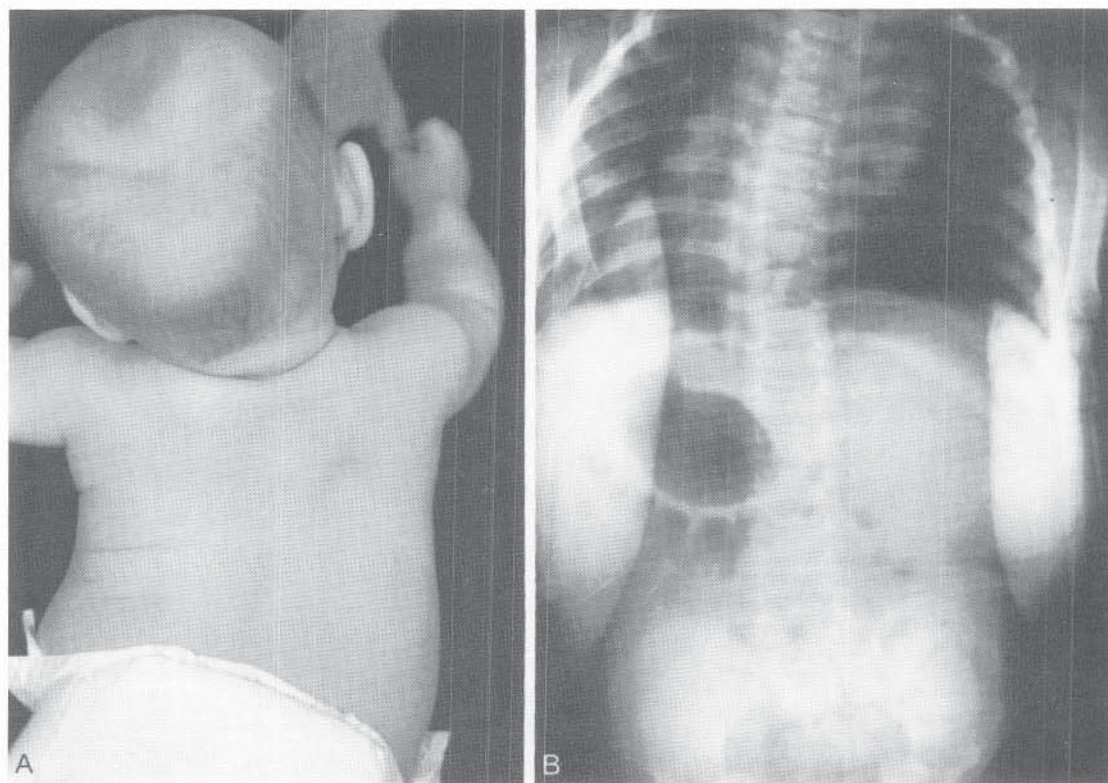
Infantile scoliosis in a 6-month-old infant. A, Plagiocephaly of the head. B, AP radiograph of spine showing scoliosis.
